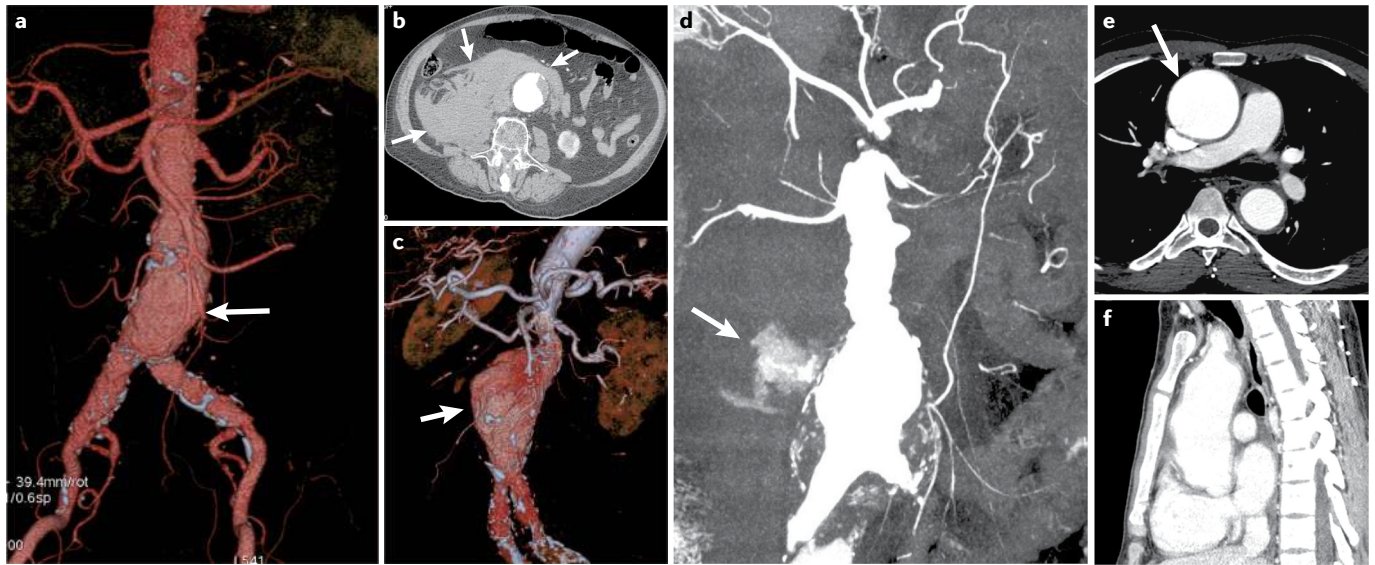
Imaging of aortic aneurysms. a | Volume-rendered, contrast-enhanced CT reconstruction showing an abdominal aortic aneurysm (AAA) in the subrenal segment (arrow), without leakage. There is evidence of atherosclerotic disease of the aortic wall, with multiple calcified plaques. b | Axial contrast-enhanced CT image showing an AAA complicated by wall leakage and active bleeding. The aneurysm is surrounded by a large haematoma contained by retroperitoneal fasciae (arrows). No blood is present inside the peritoneal cavity. c | Volume-rendered, contrast-enhanced CT reconstruction showing an AAA complicated by wall leakage
